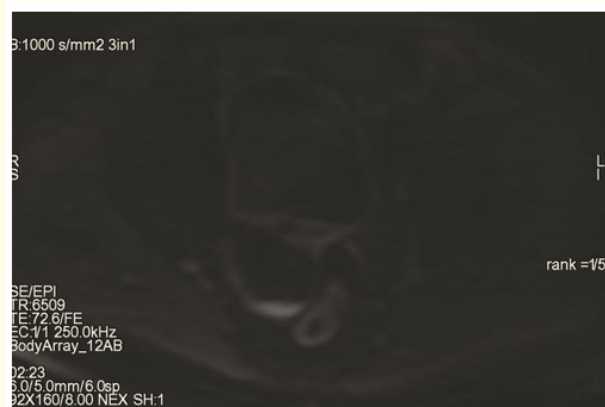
DWI axial shows intracystic hemorrhagic sediment with restricted diffusion.
